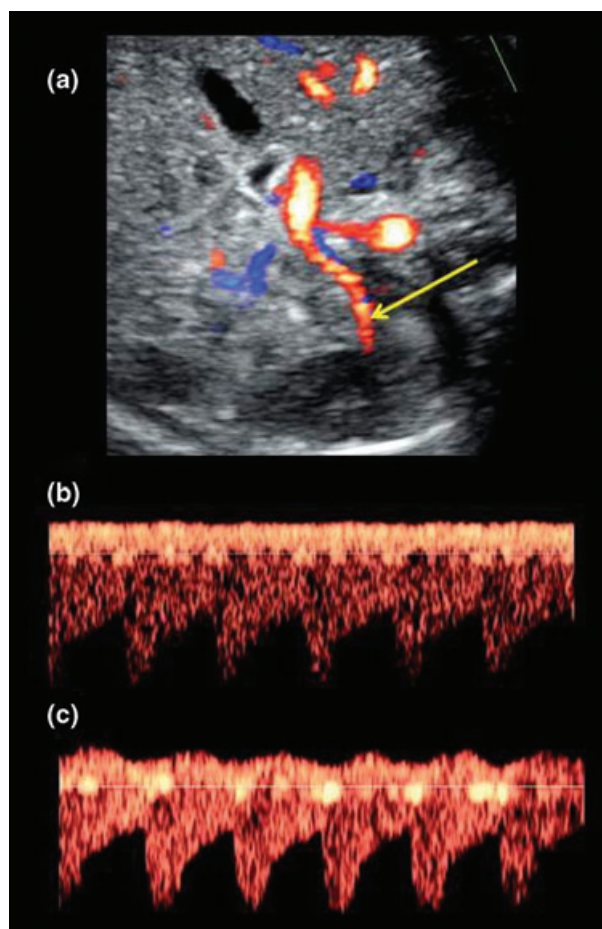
Colour Doppler image of the fetal splenic vein showing the site of measurement (arrow) of flow patterns (a), with continuous (b) and pulsatile waveforms (c). A colour version of this figure is available online.
